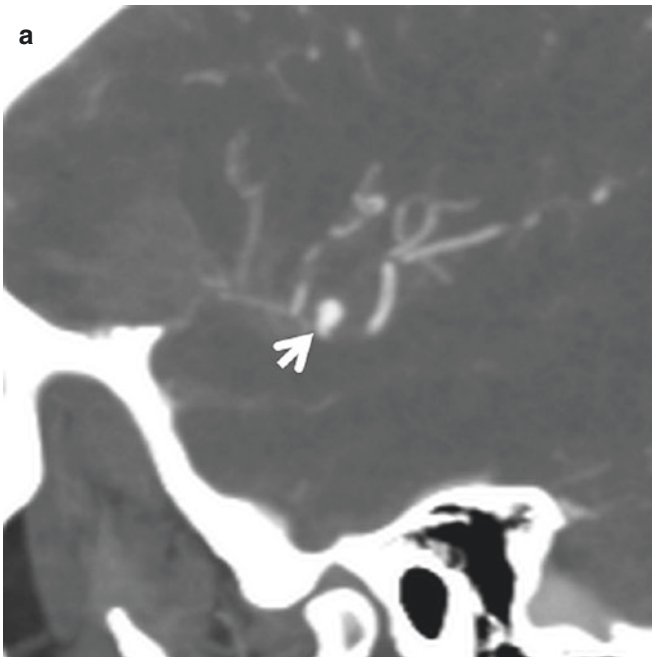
MCA aneurysm. Sagittal CTA (a) shows a right MCA bifurcation aneurysm (*arrow*), confirmed by DSA (b). Note the origins of both M2 branches are incorporated into the neck of the aneurysm
